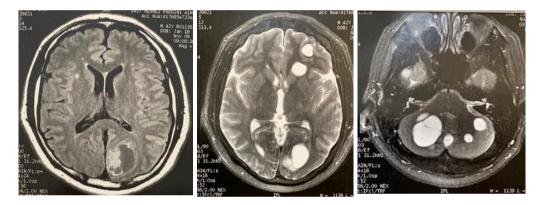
Clinical case: MRI of the brain in a female patient with lung adenocarcinoma that developed dysmetria and imbalance. The workup revealed multiple brain lesions, which after excision confirmed that they were pulmonary metastases
